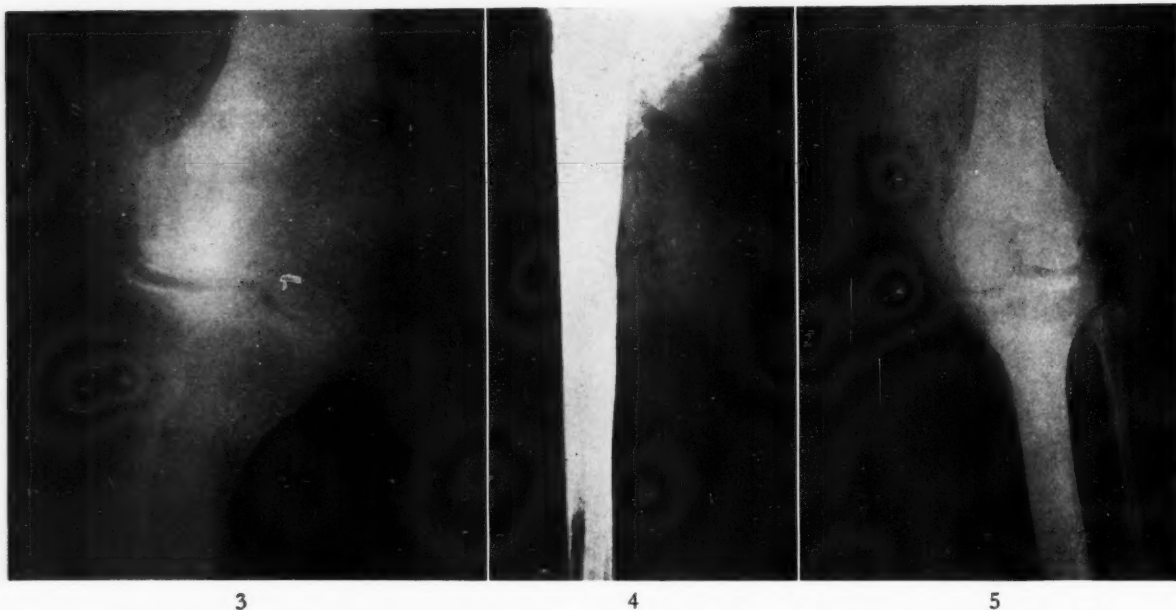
X-ray of the right knee joint on the twenty-second hospital day showing marked destruction of the internal portion of the joint space with soft tissue swelling and beginning osteomyelitis.
